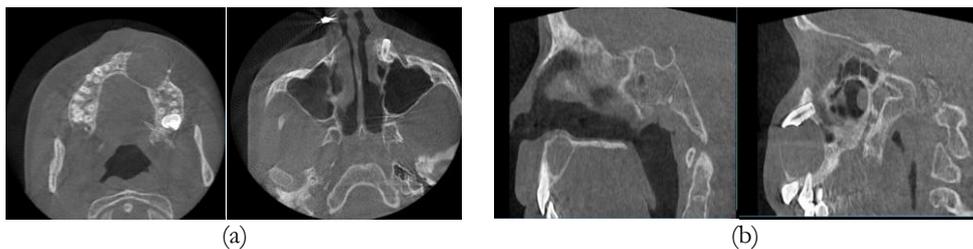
(a) represents Computed tomography (CT) Axial view, (b) sagittal view
